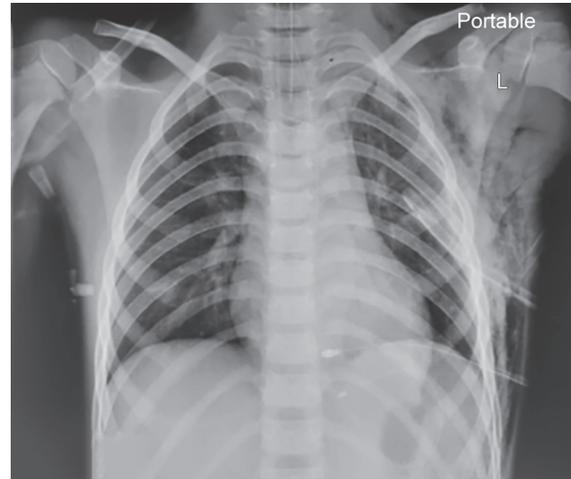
Postoperative chest radiograph
